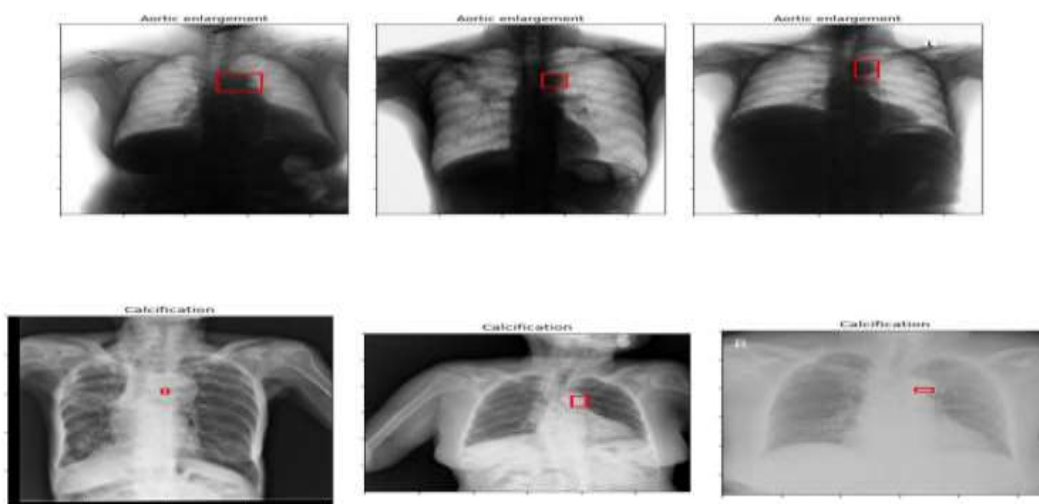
Minor Abnormalities find Through X-ray System
